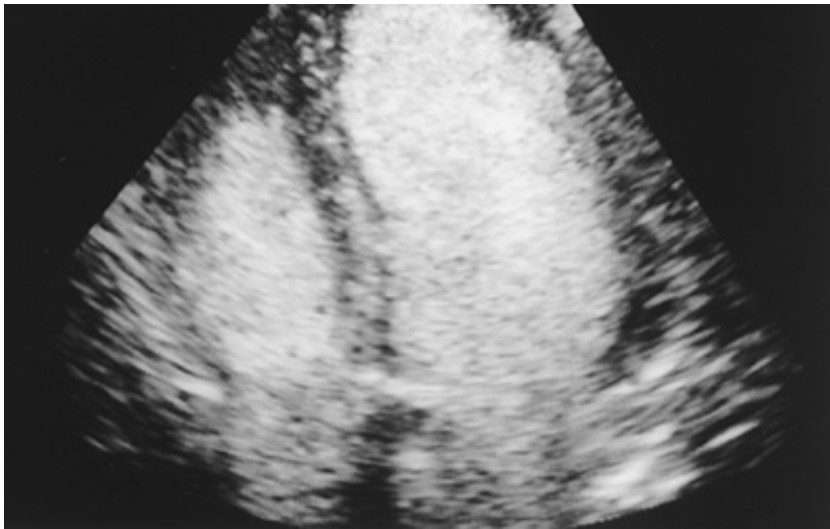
Harmonic imaging with second-generation echocardiographic contrast. Endocardial border definition before injection is fair (*upper panel*) but is markedly improved with harmonic imaging following contrast injection (*lower panel*).
